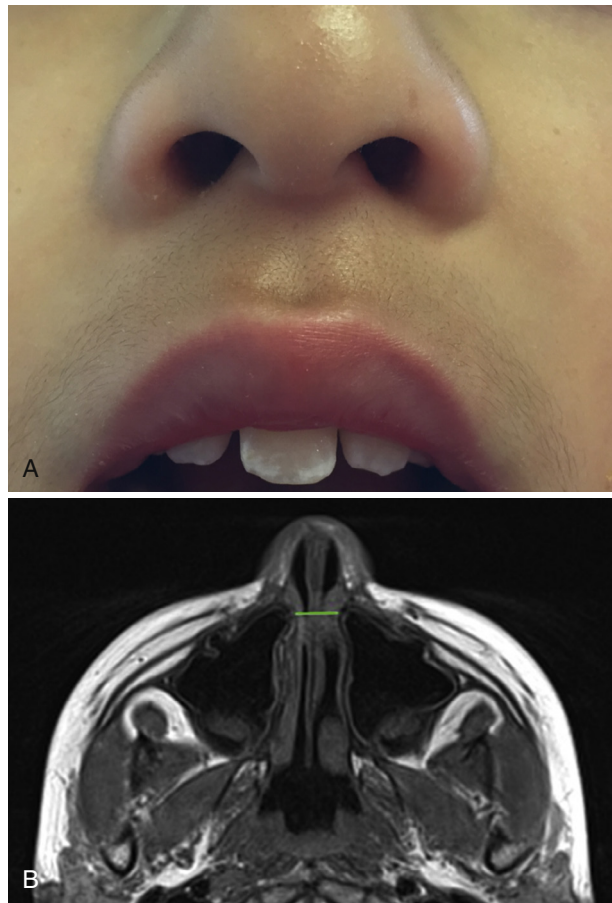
(A and B) Midline incisor associated with confirmed computed tomography evidence of pyriform aperture stenosis (<11 mm).
